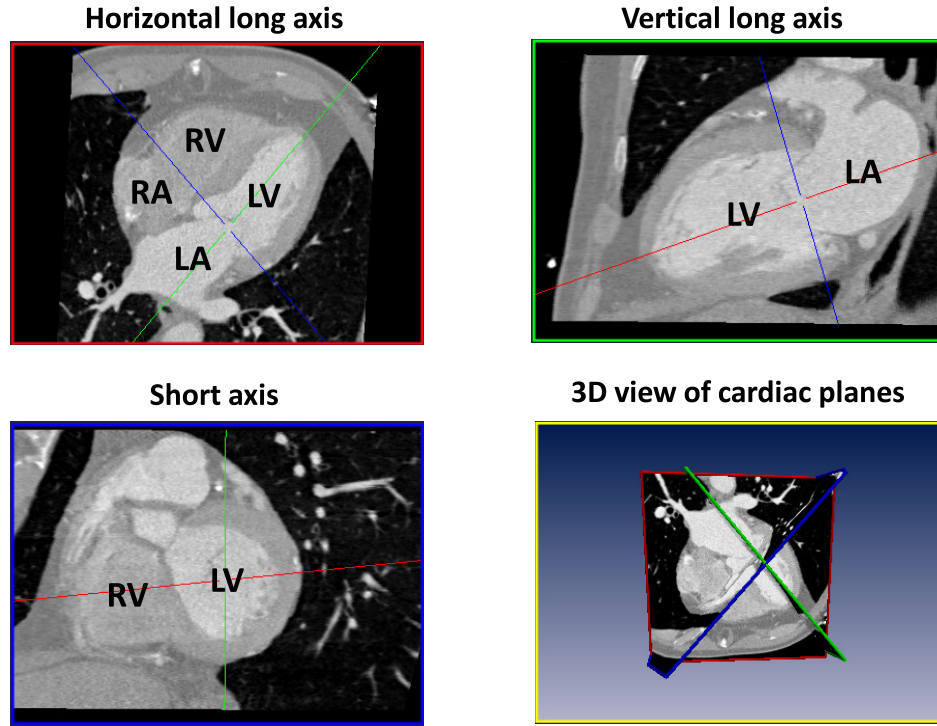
Heart anatomy as seen on a cardiac CT using the standard cardiac planes as proposed by AHA.
